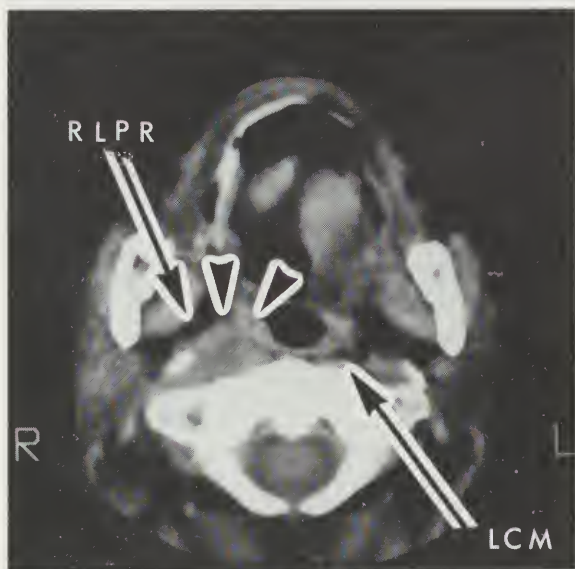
CT section demonstrated significant reduction in the size of the tumor (arrows). Right lateral pharyngeal recess (RLPR) has increased in size. Continued loss of definition of the longus coli muscle (LCM).
